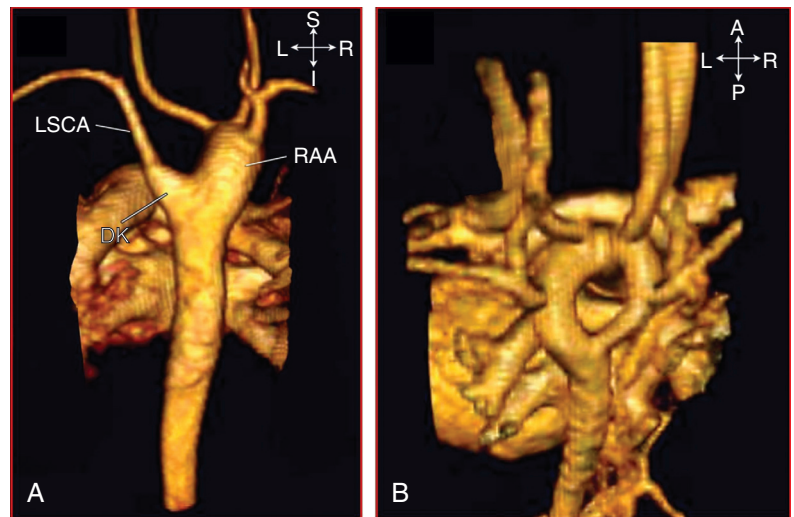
■ Three-dimensional magnetic resonance imaging reconstructions demonstrating right aortic arch (RAA), aberrant left subclavian artery (LSCA) (A), and double aortic arch (B). DK, Diverticulum of Kommerell. (Compliments of Andrew Powell, MD, Children's Hospital Boston.)
